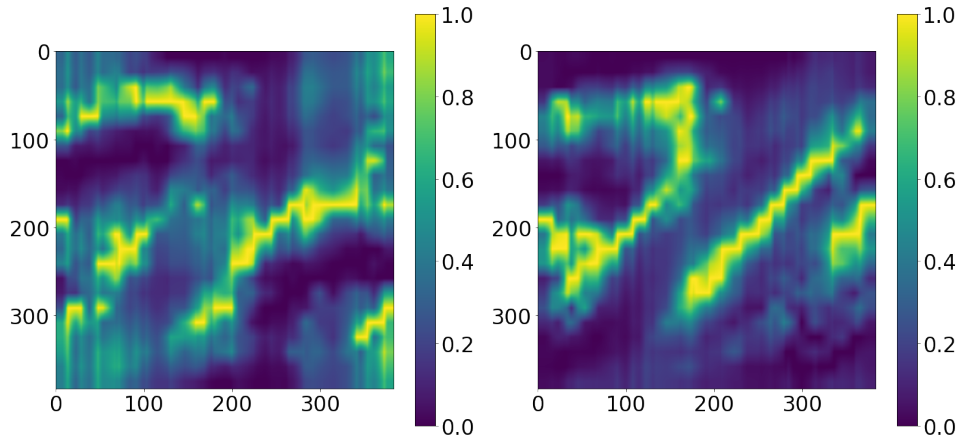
Class attention maps averaged over 30 samples of the brain tumor MRI classification dataset for supervised Transformer (on the left) and CASS trained Transformer (on the right).
